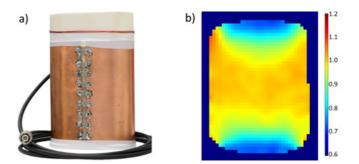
a) The final STS coil optimized for use in hand & wrist imaging in a 0.1 T MRI system. b) Central slice of an experimentally acquired map of the coil's trans mit field B1 (picture: M. Spreiter, AMT Center)
